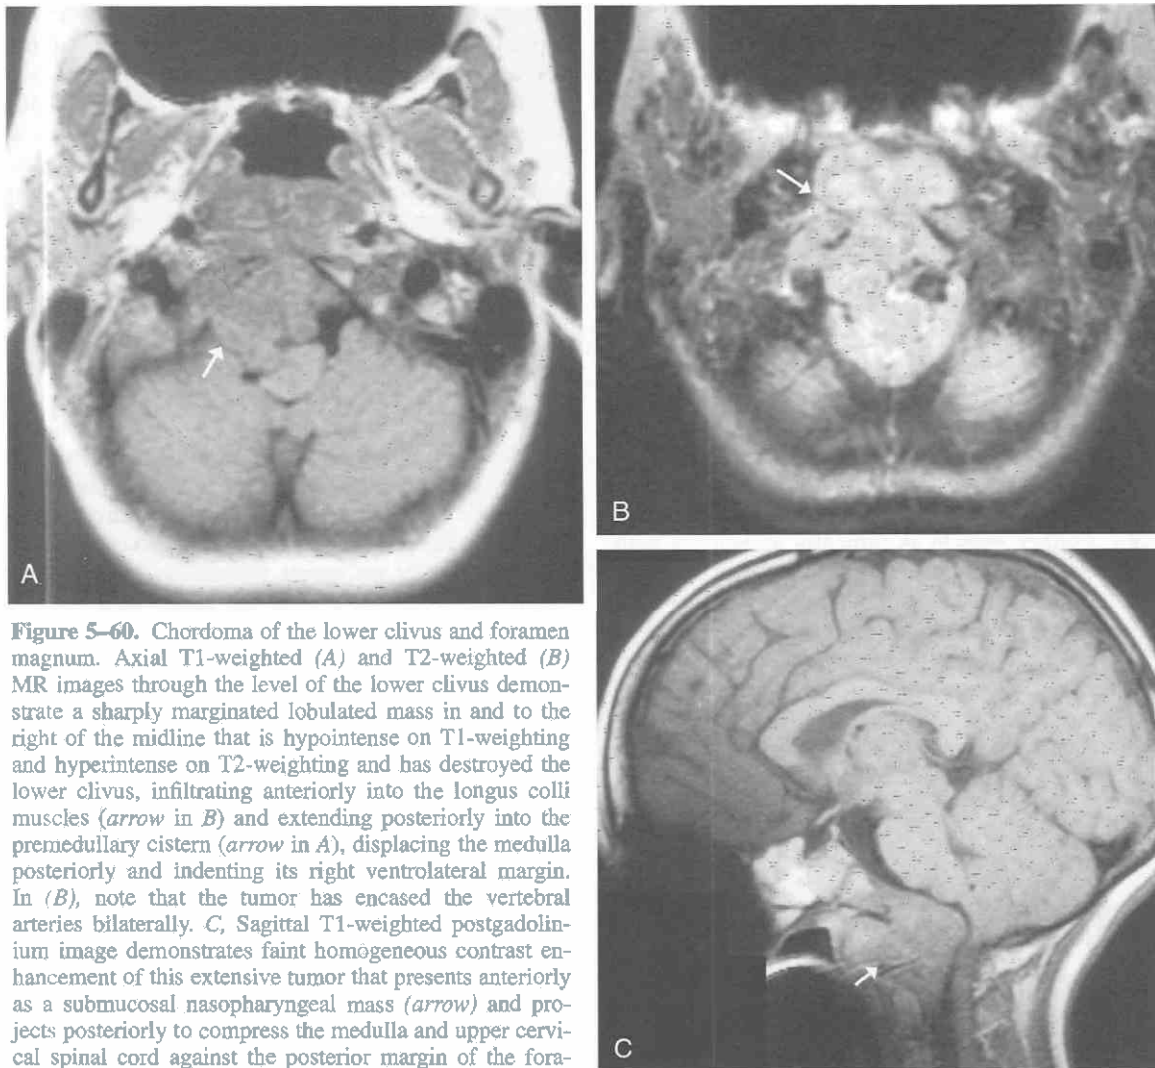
Chordoma of the lower clivus and foramen magnum. Axial T1-weighted (A) and T2-weighted (B) MR images through the level of the lower clivus demonstrate a sharply margined lobulated mass in and to the right of the midline that is hypointense on T1-weighting and hyperintense on T2-weighting and has destroyed the lower clivus, infiltrating anteriorly into the longus colli muscles (arrow in B) and extending posteriorly into the premedullary cistern (arrow in A), displacing the medulla posteriorly and indenting its right ventrolateral margin. In (B), note that the tumor has encased the vertebral arteries bilaterally. C, Sagittal T1-weighted postgadolinium image demonstrates faint homogeneous contrast enhancement of this extensive tumor that presents anteriorly as a submucosal nasopharyngeal mass (arrow) and projects posteriorly to compress the medulla and upper cervical spinal cord against the posterior margin of the foramen magnum.
